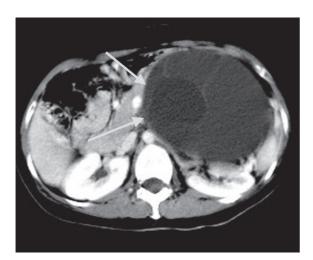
Mucinous cystic tumor in a 37-year-old female. CT shows a large multiloculated mass at the pancreatic tail (arrows). Each cyst is larger than 2 cm.
